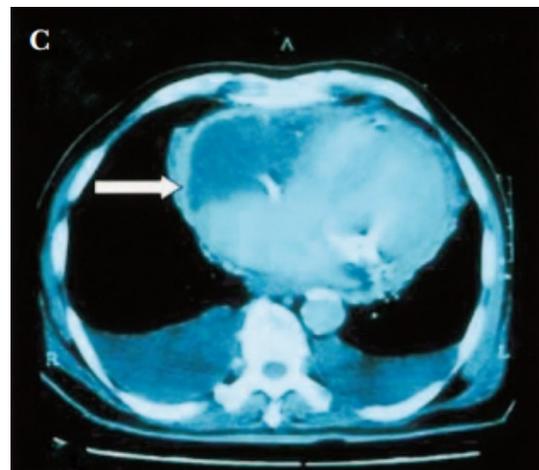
Computed tomography shows pericardium and cystic mass
